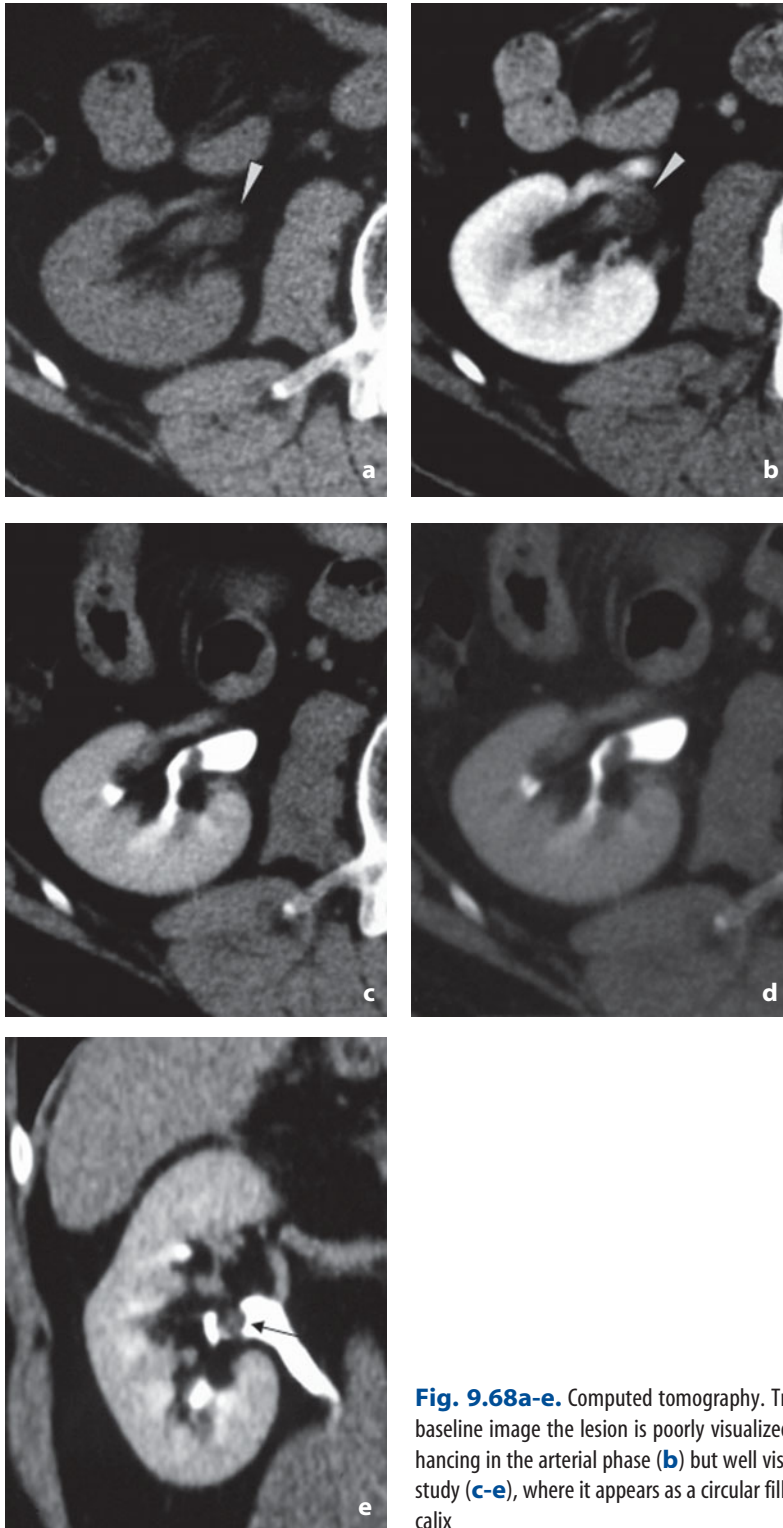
Computed tomography. Transitional cell carcinoma. a In the baseline image the lesion is poorly visualized (*arrowhead*). The mass is nonenhancing in the arterial phase (b) but well visualized in the delayed phase of the study (c-e), where it appears as a circular filling defect attached to the wall of a calyx
